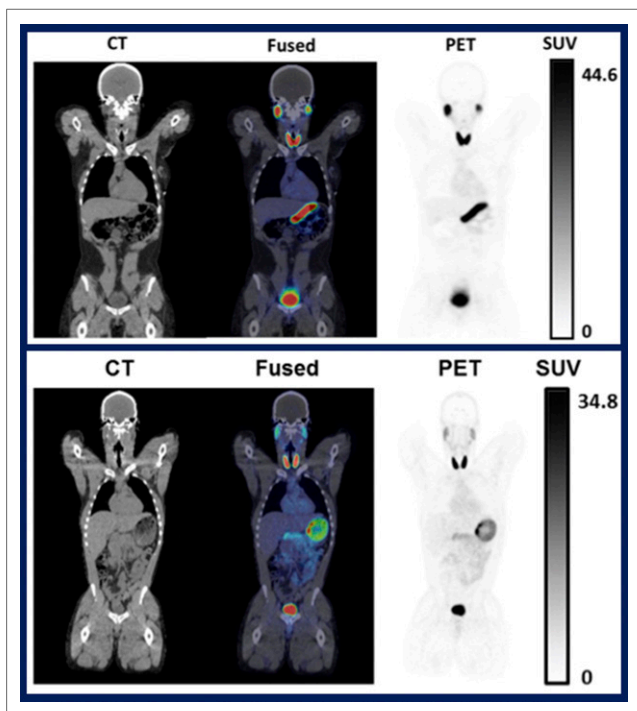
Top: Coronal ^{18}F -TFB PET/CT images (left, CT; middle, fused; right, PET) at 2.5 hours after injection in a healthy woman. Activity in the salivary glands, thyroid, stomach, and bladder excretion are clearly visible. Bottom: Corresponding images in a healthy man. ^{18}F -TFB is an iodide analogue with potential for imaging of differentiated thyroid cancer and as a sodium iodide gene reporter probe.
